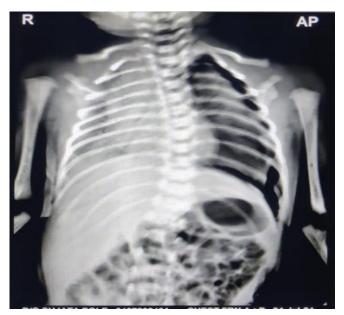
X-Ray Showing a clear absence of lung markings on the left side, with a distinct visceral pleural line indicating the collapsed lung. The left hemithorax appears more radiolucent compared to the right. Additionally, there is a slight mediastinal shift towards the right side, suggesting a significant pneumothorax. In view of progressive pneumonitis changes intravenous antibiotics were escalated to ceftriaxone (MONOCEF) and vancomycin. A diagnostic pleural tap performed on the 20th of May revealed a sterile effusion with AFB negative for TB NAAT, thus excluding tuberculosis. Consequently, the patient was continued on antibiotic therapy, received supportive care, and nutritional rehabilitation was initiated.
